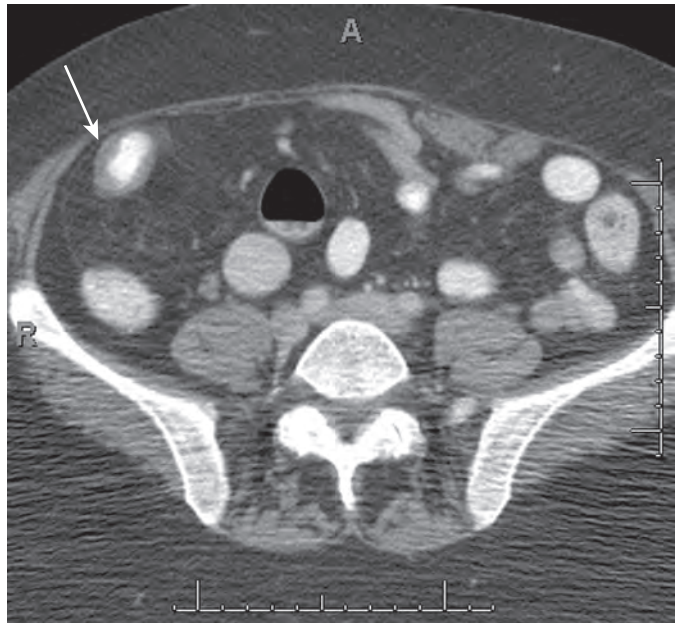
Crohn's disease. Axial CT in a patient with Crohn's disease. CT demonstrates a thickened small bowel loop (arrow) surrounded by normal-appearing small bowel loops.
